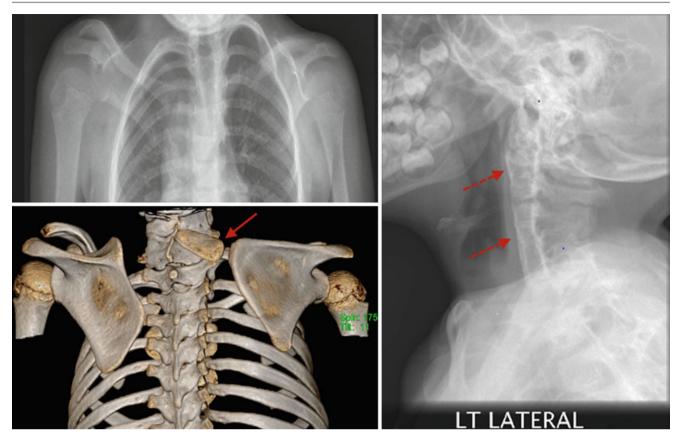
Radiological findings in Sprengel shoulder. Plain radiographs and 3D CT-scan of a child with a right Sprengel shoulder. The right scapula is high riding. Cervical vertebrae fusion (*dashed arrows*) and omovertberal bony connection (*solid arrow*)
